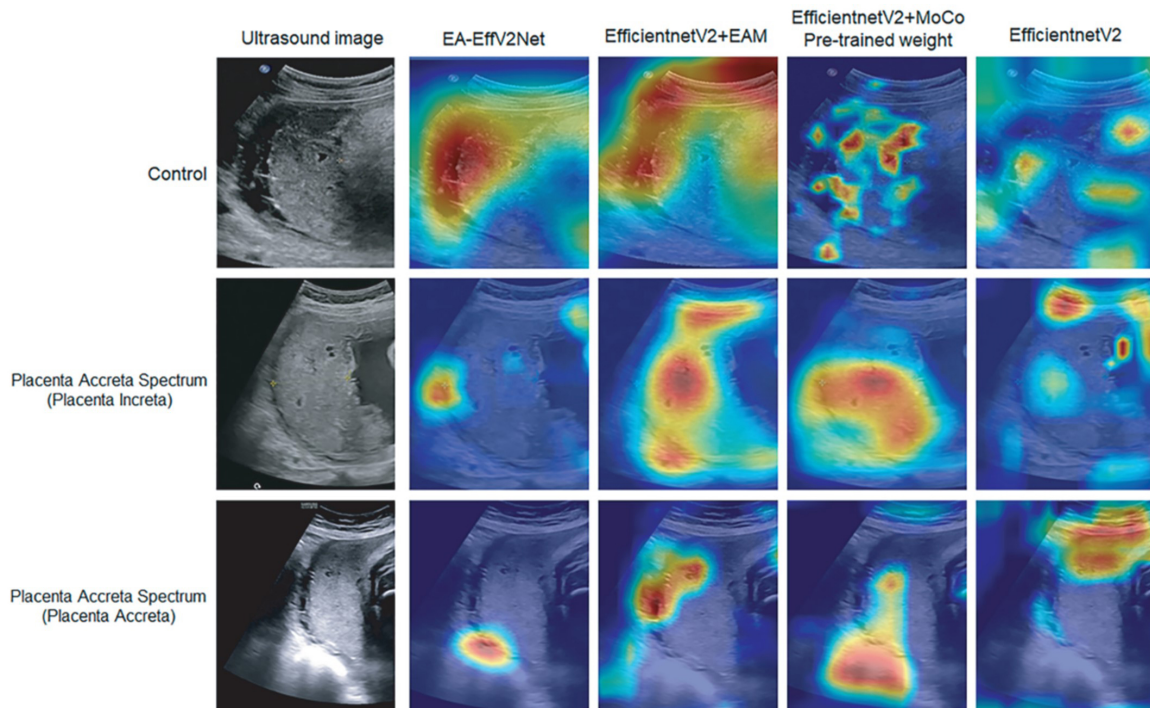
Visualizations of the models in ultrasound images by Grad-CAM. The first row shows heatmaps of the ultrasound images without PAS. The second and third rows show heatmaps of the ultrasound images with PA and PI, respectively. Ultrasound images are obtained transabdominally by color Doppler ultrasound diagnostic instrument (Samsung HERA W10, USA) with a CA 2-9A convex array probe. The frequency was set to 2.0-9.0 MHz. Each pregnant woman assumed a supine position, with the bladder appropriately filled and the lower abdomen fully exposed. Images with the largest area of connection between the placenta and the uterus were displayed on the same screen, captured, and saved in the Joint Photographic Experts Group format. Grad-CAM, gradient-weighted class activation mapping; PA, placenta accreta; PAS, placenta accreta spectrum; PI, placenta increta.
